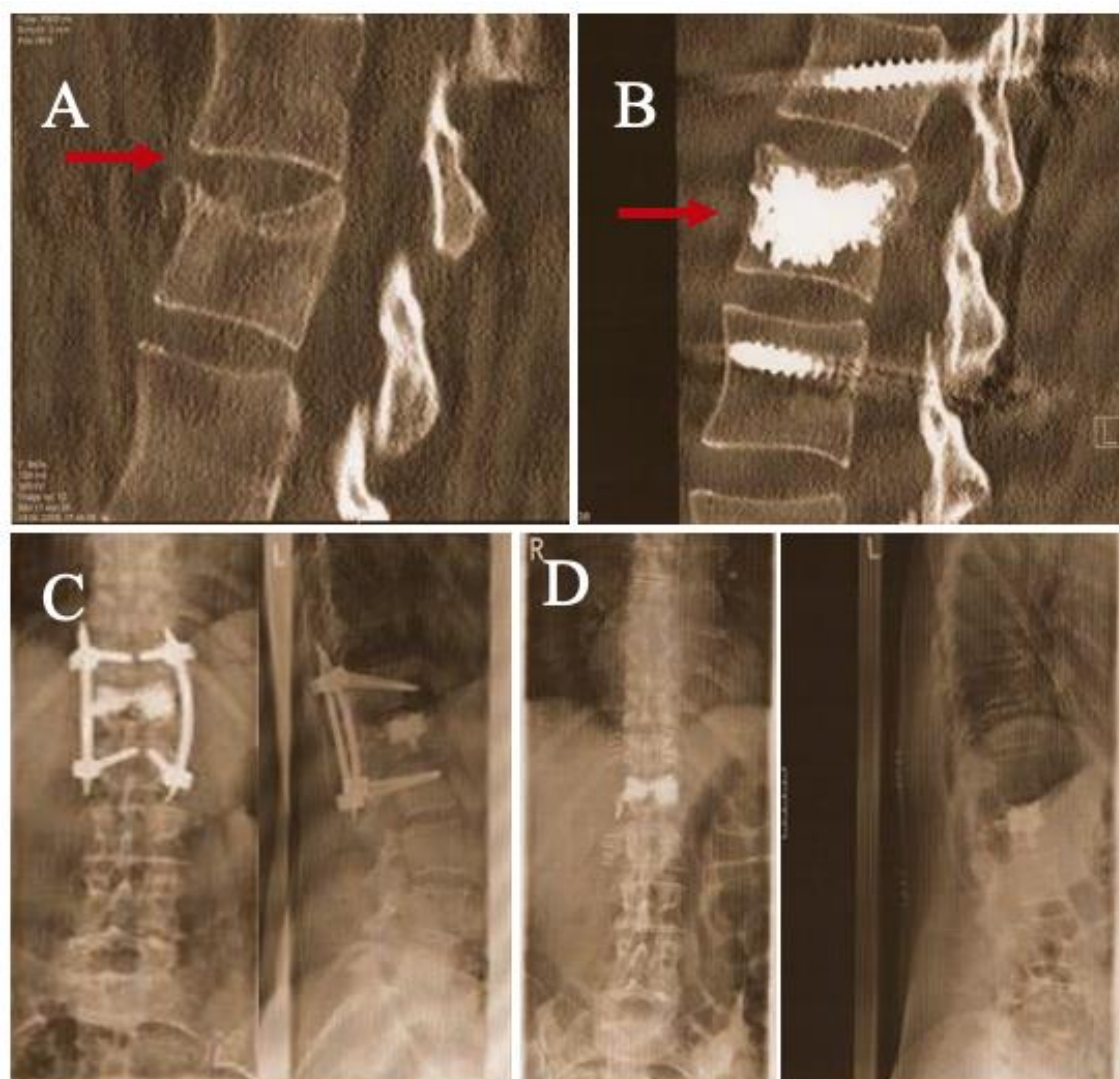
Case 1. (A) Sagittal reconstructed CT showing A.3.1 fracture (red arrow) (B) Postoperative sagittal reconstructed CT scan of the same patient showing the surgical treatment of the fracture and reversal of the kyphosis (red arrow) (C) Postoperative plain X-ray antero-posterior and lateral views of the same patient showing minimal loss of reduction after 2 years (D) Postoperative plain-X-ray after removal of the percutaneous stabilizing system after 2 years.
